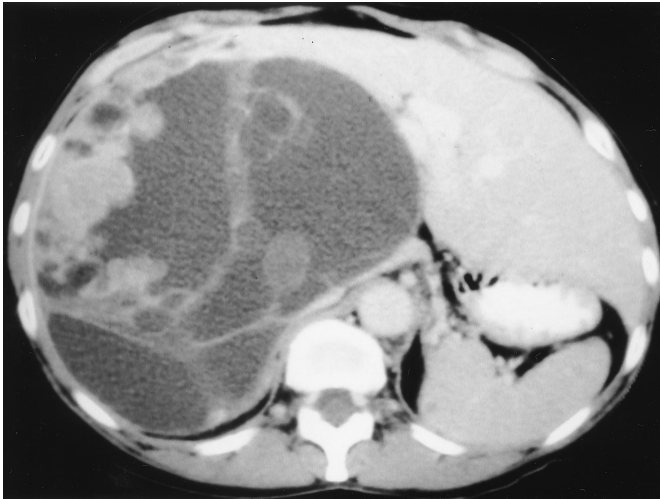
A. CT appearance of polycystic liver disease associated with minor renal cystic disease. The patient required orthotopic liver transplantation. B. Explanted liver.
